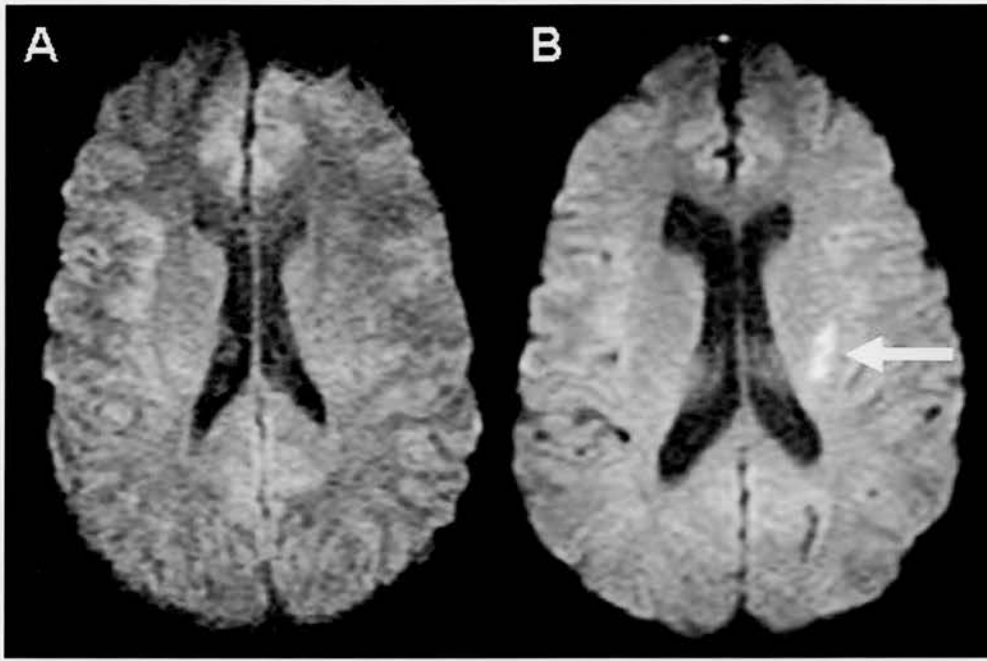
A shows an example of a patient with a DWI negative scan. B shows an example of a patient with a DWI positive scan. The white arrow identifies the DWI hyperintensity.
